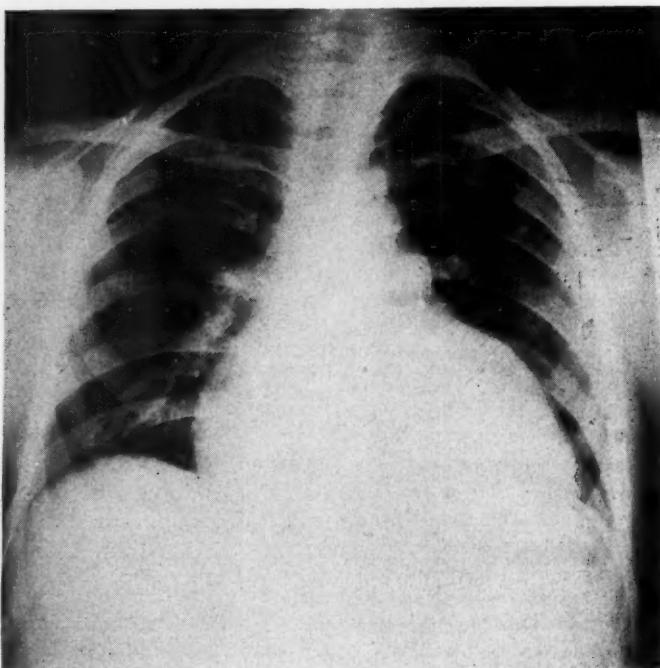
Roentgenogram of the thorax made 13 days after operation, showing a marked reduction in the size of the heart and the absence of pulmonary congestion.
